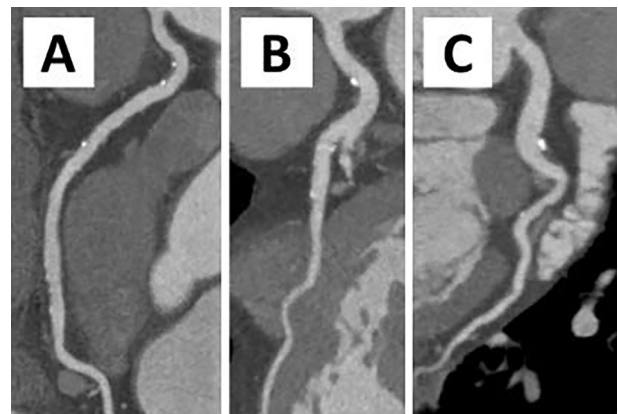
Coronary CT angiography of the right coronary artery (A), left anterior descending artery (B), and left circumflex coronary artery (C). Coronary arteries exhibit mild sclerotic change without significant stenosis.
